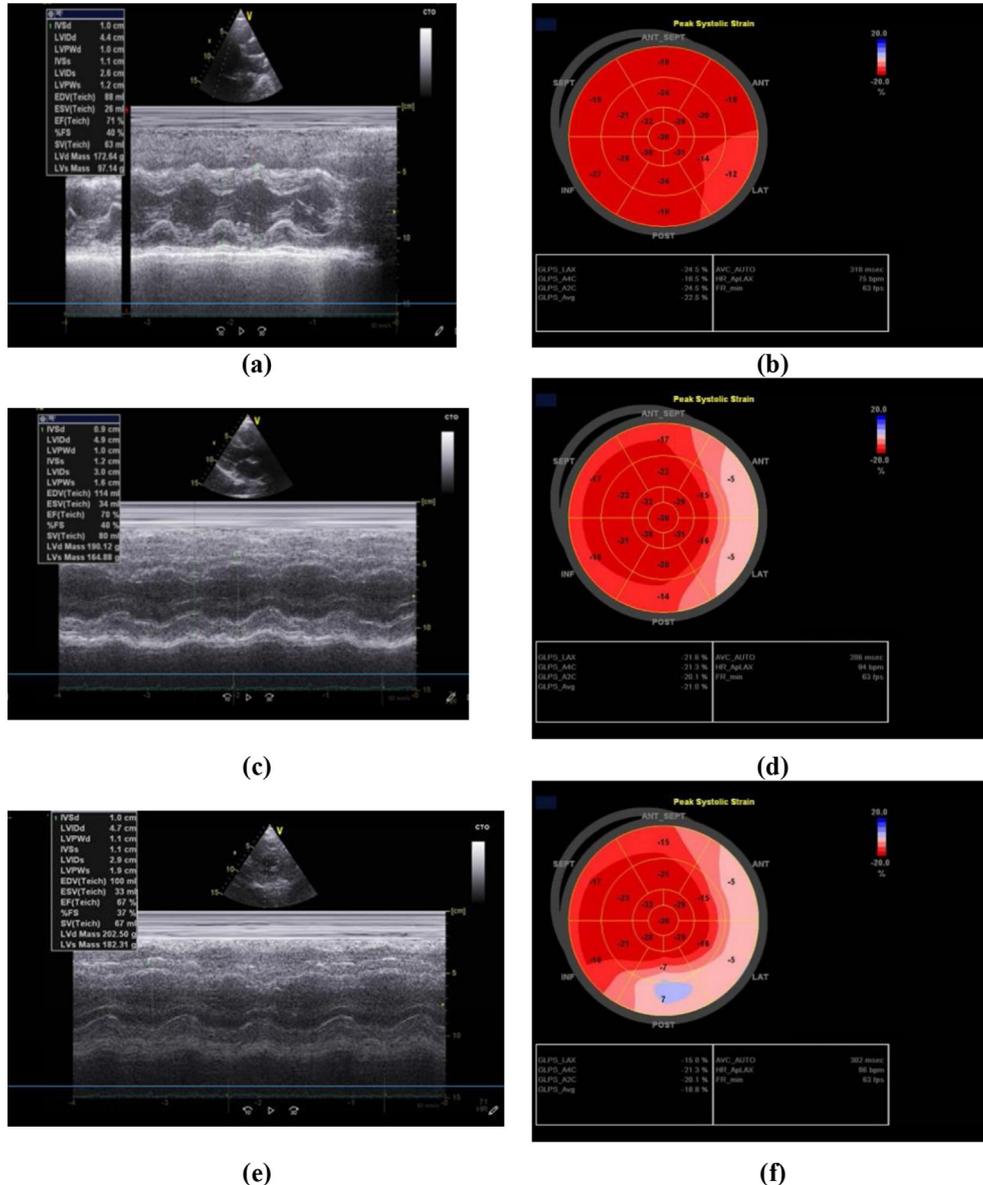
Female patient aged 36 years, not known to be diabetic, not hypertensive, non-smoker, overweight with BMI=25 kg/m<sup>2</sup>, not known to be cardiac, no thyroid or chest diseases, diagnosed as breast cancer. She was planned to receive doxorubicin. On the first visit (V1): (a, b): baseline echocardiography showed no significant abnormal echo-doppler data, EF=71% and GLS=-22.5%. On the second visit (V2): she received 215 mg/m<sup>2</sup> of doxorubicin, only complaining of loss of appetite, echocardiographic examination (c, d) showed: EF=70% and GLS=-21% with AbGLS=1.5 and  $\Delta$ GLS=6.7%. On the third visit (V3): the cumulative dose reached was 427 mg/m<sup>2</sup>, echocardiographic examination (e, f) showed: EF=67% and GLS=-18.8%, AbGLS=3.7,  $\Delta$ GLS=16.4% (Significant reduction in GLS or subclinical cardiotoxicity). (a, c, e): 2D echocardiographic examination for assessment of LVEF by M-mode. (B, D, F): Strain echocardiography examination to measure GLS showing Bull's eye.
